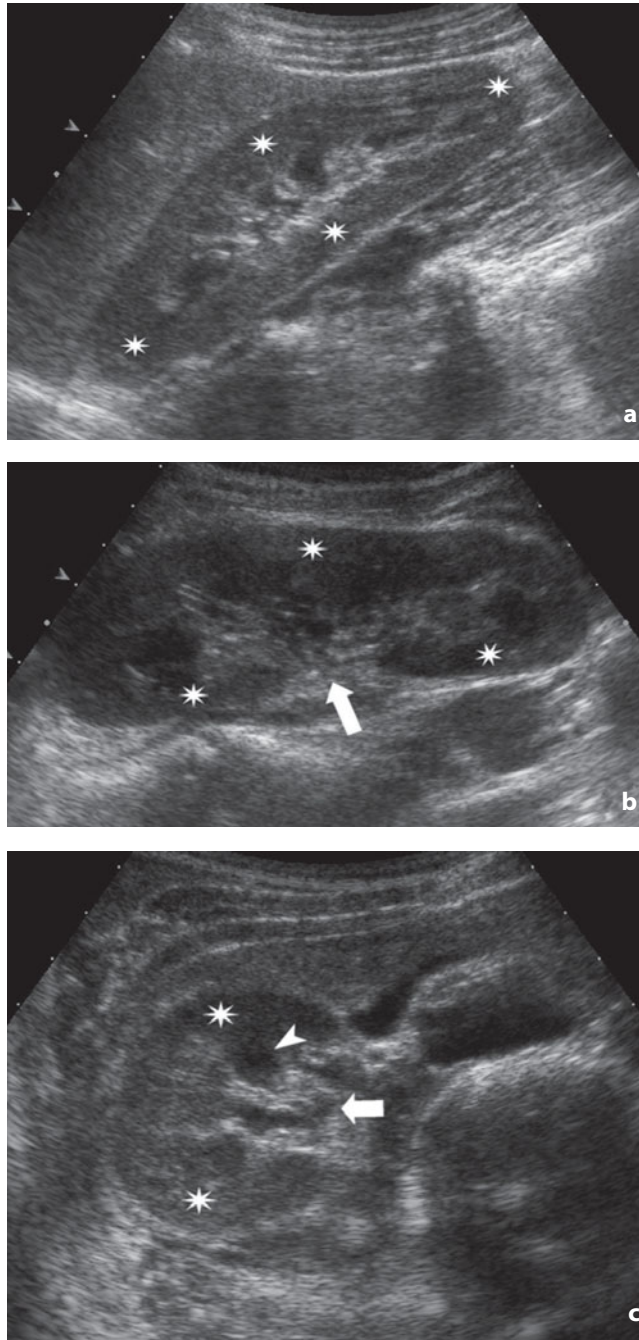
Ultrasonography. Kidney. a Anterior longitudinal scan. The cortical ring (*asterisks*) appears continuous. b Posterior oblique longitudinal scan. The cortical ring (*asterisks*) appears interrupted at the level of the renal hilum (*arrow*). c Anterior axial scan. The kidney is cut along the short axis. The sonogram shows the cortex (*asterisks*), the pyramids (*arrowheads*) and the renal sinus (*arrow*)
